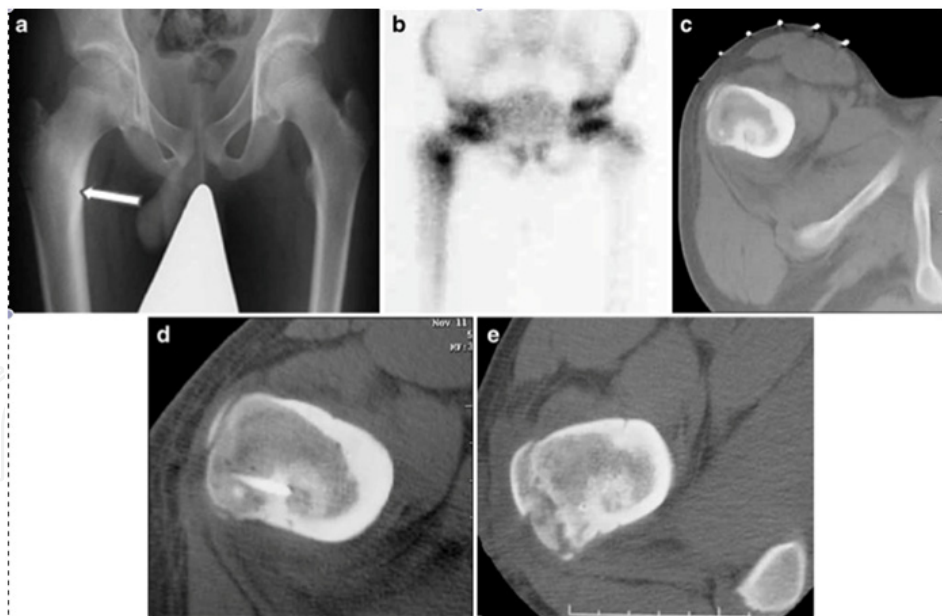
Technique of RFA of osteoid osteoma in a 12-year-boy with chronic right hip pain. a Radiograph of the pelvis shows an ill-defined area of dense sclerosis in the medial aspect of the proximal femoral shaft (arrow). b Bone scan shows active uptake at the site of the dense sclerosis consistent with the diagnosis of osteoid osteoma. c CT scan shows the nidus located deep to the cortex and surrounded by dense new bone. The radiopaque markers on the skin surface are for planning the skin entry point. d Axial 1-mm CT slice shows the correct position of the tip of the RF electrode within the centre of the nidus. e Follow-up CT after 15 months shows sclerosis within the nidus (12)
